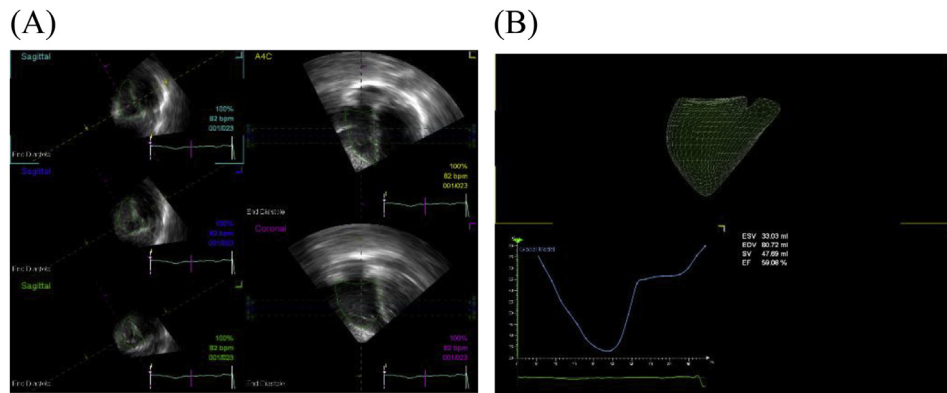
The stepwise process of right ventricle (RV) reconstruction by 3D echocardiography. (A) Having traced endocardial borders in three orthogonal views, the border tracking results are displayed for inspection. Note how the purple guideline (indicated by the purple asterisk) bisects the tricuspid valve and RV outflow tract in the short-axis views. This corresponds to the coronal RV reconstruction (highlighted), with clearly delineated RV inflow and outflow portions. (B) RV volume is calculated and displayed.
